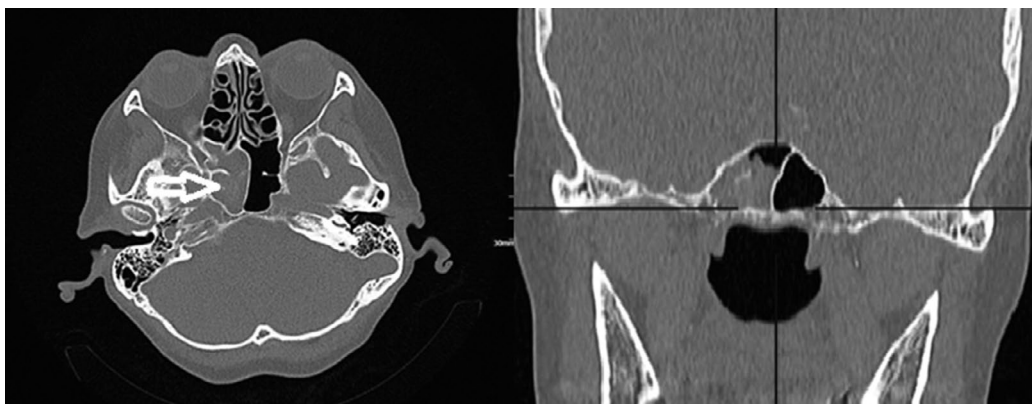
Multislice computed tomography of the paranasal sinuses (2023), sagittal and coronal views. A hyperdense lesion with a solid component (*fungal ball*) and an area of calcification (*arrow*) is observed in the right sphenoid sinus, which is characteristic of a mycetoma. No signs of bony destruction are detected.
